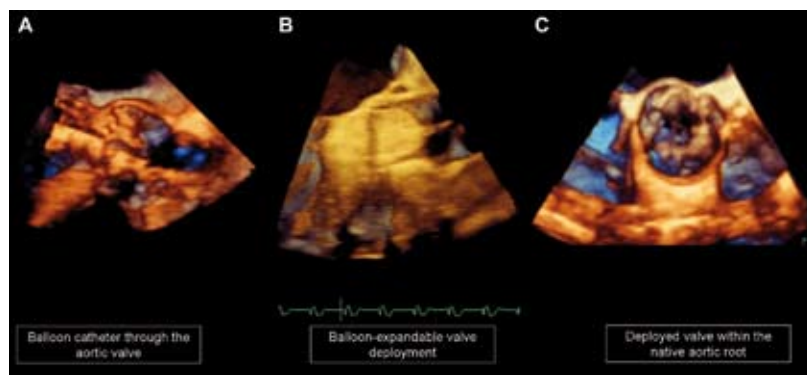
Three-dimensional transesophageal echocardiography during transcatheter aortic valve implantation procedure. First, the balloon catheter through the aortic valve is visualized (left panel) and subsequently, balloon dilatation of the aortic valve is performed. After deployment of the balloon-expandable prosthesis (middle panel), the function and position of the implanted valve can be assessed (right panel).
